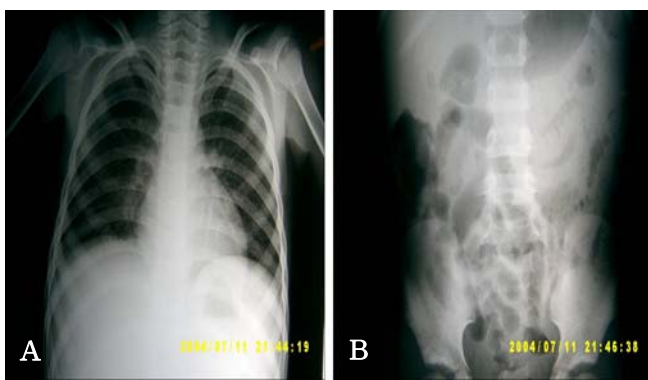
(A) Plain film of the chest shows a snowflake appearance in both lungs. (B) Plain film of the abdomen demonstrates paralytic ileus with widening of the interloop distance.
